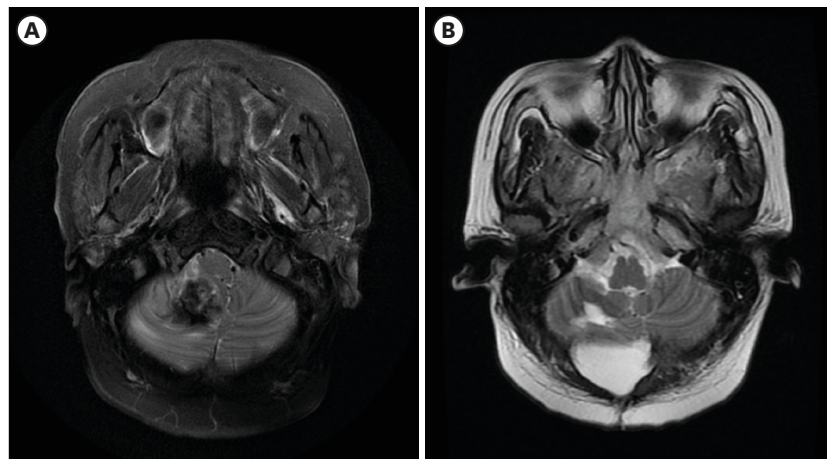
Gestational trophoblastic neoplasia with cerebellar metastasis. (A) Before craniotomy, T2-weighted MR image showed hemorrhagic metastatic tumor at the right cerebellar hemisphere with peritumoral edema, compression of medulla and the fourth ventricle, midline shift. (B) One month after craniotomy, T2-weighted MR image showed postoperative cystic lesion at the right cerebellar hemisphere, with normal medulla and the fourth ventricle. MR, magnetic resonance.
